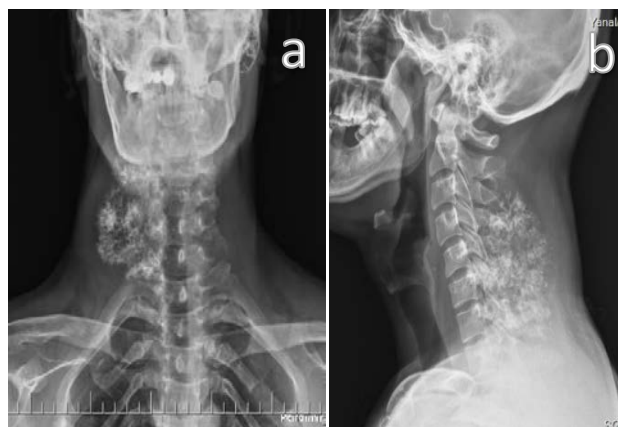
Preoperative anteroposterior and lateral cervical spine radiograph
